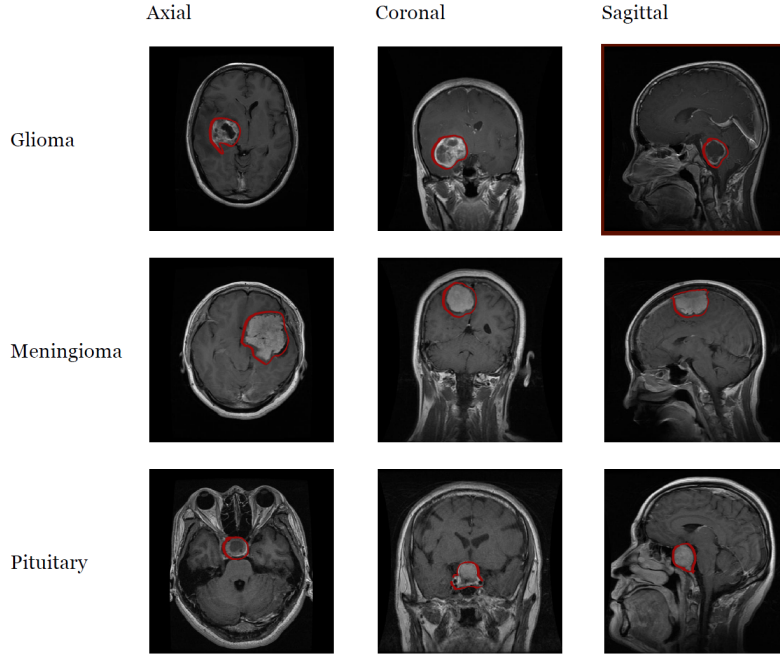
T1-weighted MRIs of 3 types of brain tumors, 1. Glioma, 2. Meningioma, and 3. Pituitary. Images are in 3 cross-sectional positions of 1. axial, 2. coronal, and 3. sagittal.
